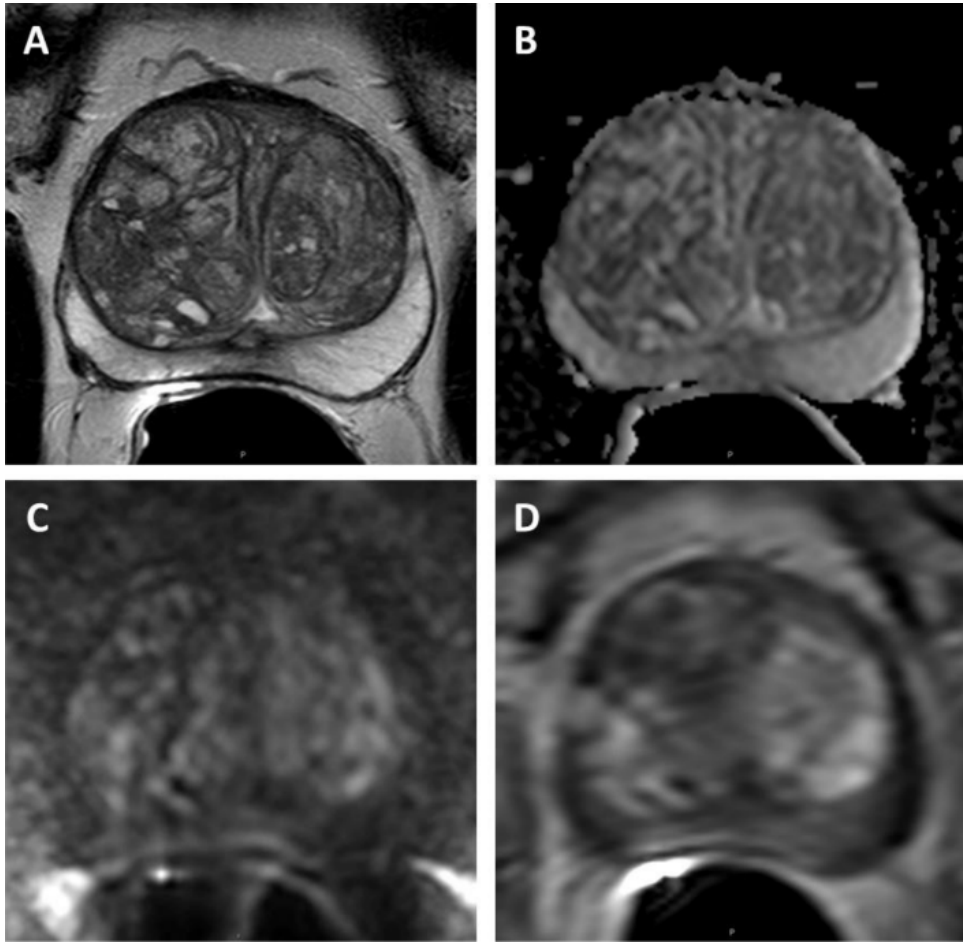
Images from a prostate mpMRI exam: A) T2W image, B) ADC map, C) DWI image, and D) DCE image (American College of Radiology, 2019).
